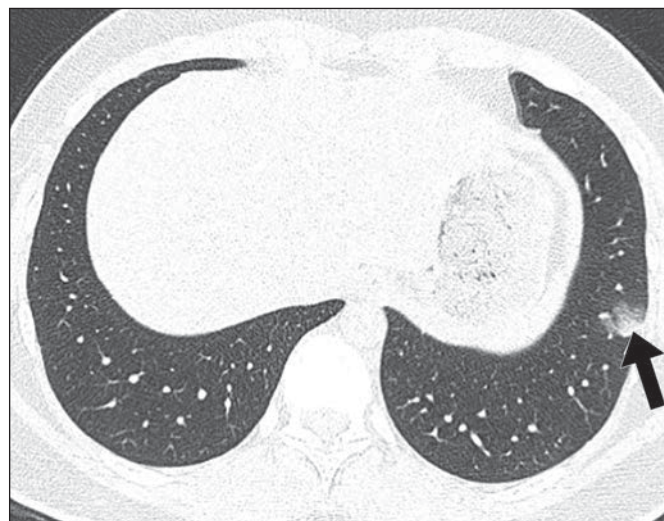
27-year-old man with Middle East respiratory syndrome (case 1). Patient was smoker who was healthy otherwise. CT was performed 8 days after admission and 20 days after onset of symptoms. Patient was eventually discharged. A, Upper lung CT image shows bilateral subpleural ground-glass opacities (arrows) and ill-defined centrilobular ground-glass nodules (arrowhead). B and C, Two lower lung CT images show large right lower lobe (arrow, B) and small focal left lower lobe (arrow, C) subpleural consolidations.
